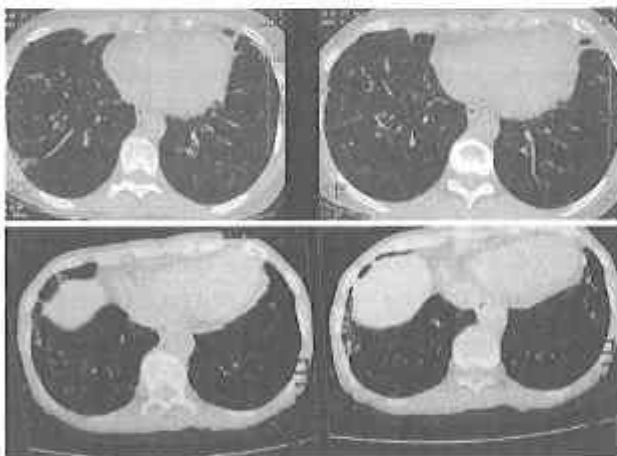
HRCT with peripheral and central bronchiectatic changes 12 years ago (above) and now. (below)
